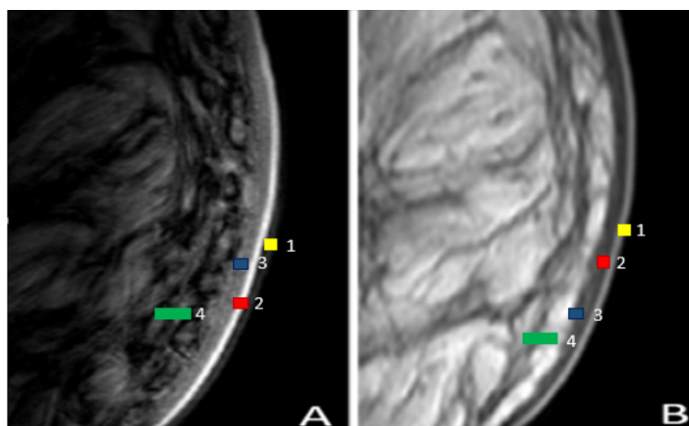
MRI sequences. (A) T1 sequence, (B) T2 sequence. 1: Stratum Corneum, 2: Epidermis, 3: Dermis, 4: Hypodermis
